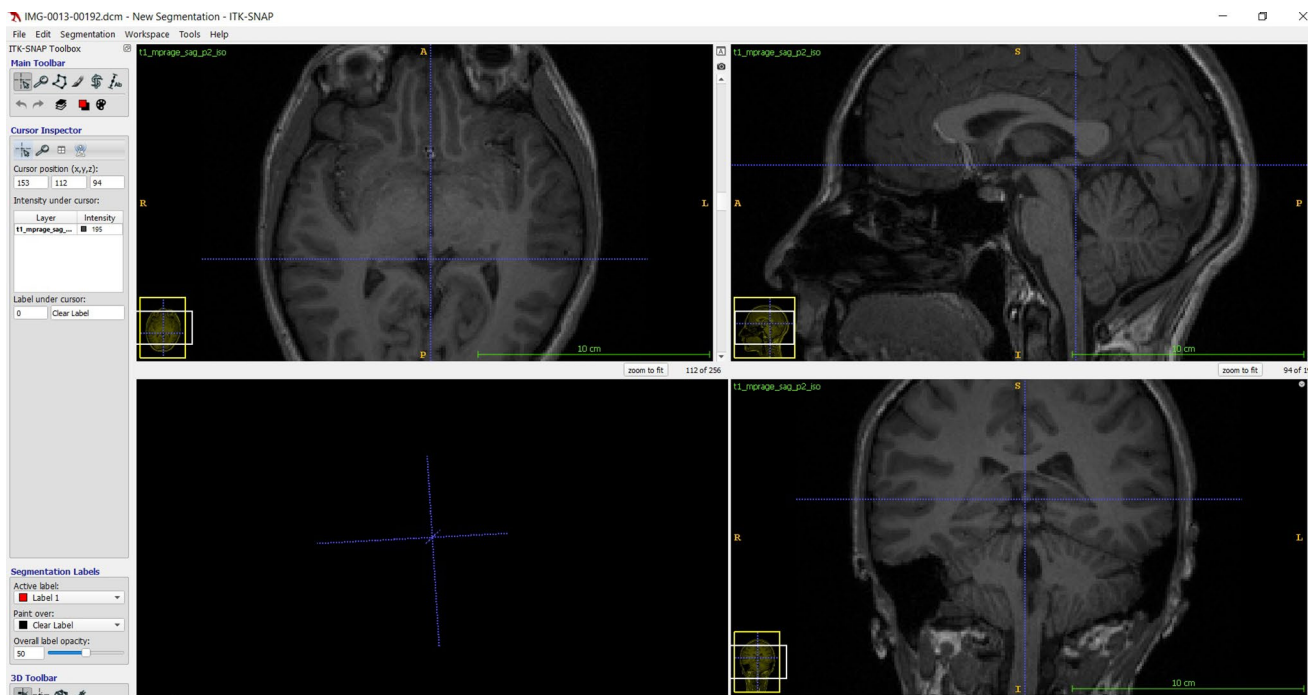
Determination of the pineal gland according to the anatomical landmarks at T1-weighted magnetization prepared with MPRAGE sequence
